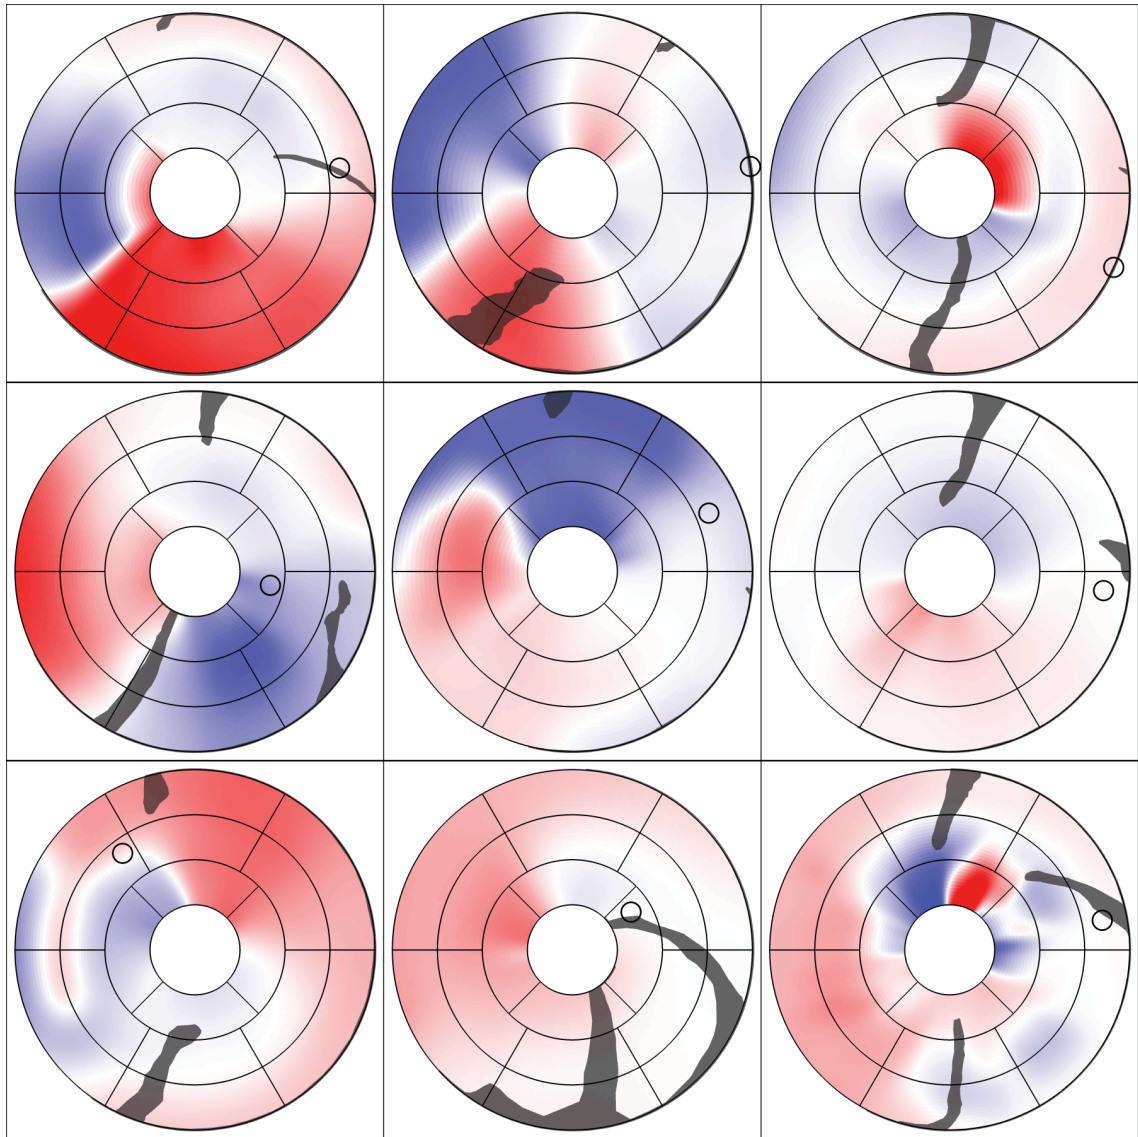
Dyssynchrony maps created using radial contraction curves from short-axis cine SSFP MR images. Red indicates early contraction, while blue represents late contracting regions. LV lead positions are shown with black circles and coronary veins from MRI are overlaid in gray.
